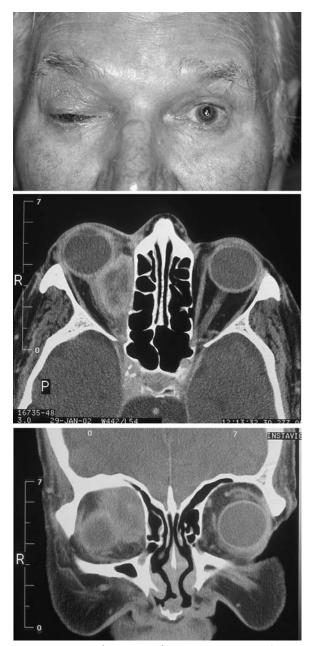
Mass formation of a metastatic tumor (squamous cell carcinoma), presenting as a large space-occupying lesion, superior medial to the globe in the right orbit. The axial CT image reveals the necrotic nature of the tumor core, indicating a rapid growth. The mass was causing inferior lateral proptosis and extraocular motility problems. The primary of this lesion was unknown despite extensive workup, including thorough consultations with ear, nose, and throat specialists.
